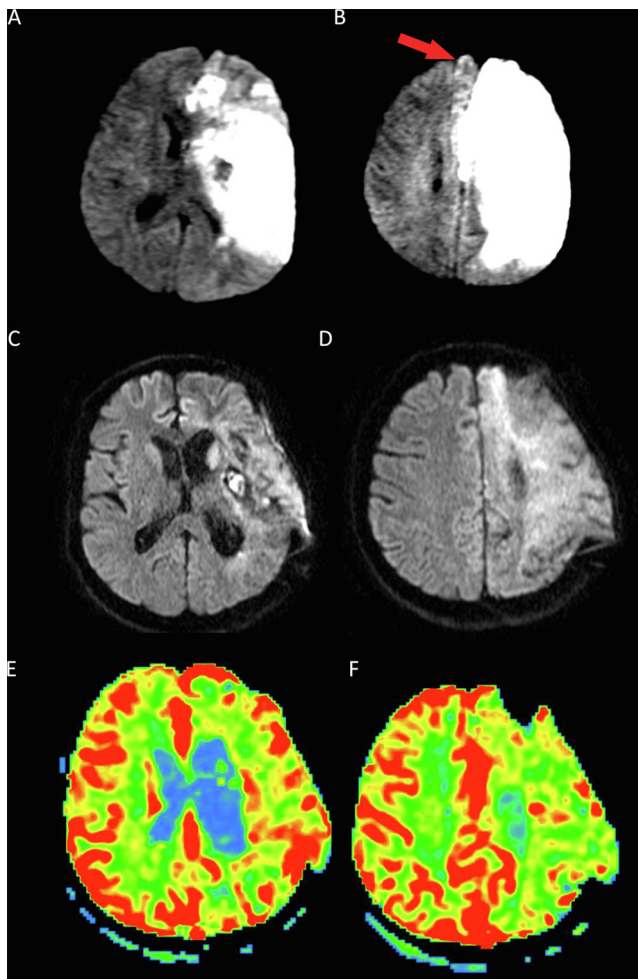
A, B: Pre-operative diffusion weighted MR images. A massive left hemispheric infarction is seen. Red arrow shows ischemic cortical areas on the contralateral side. C, D: Post-operative diffusion weighted MR images. The infarction and brain shift are seen to be resolved. E, F: Post-operative perfusion weighted radiologic images, which show adequate perfusion in both cerebral hemispheres.
